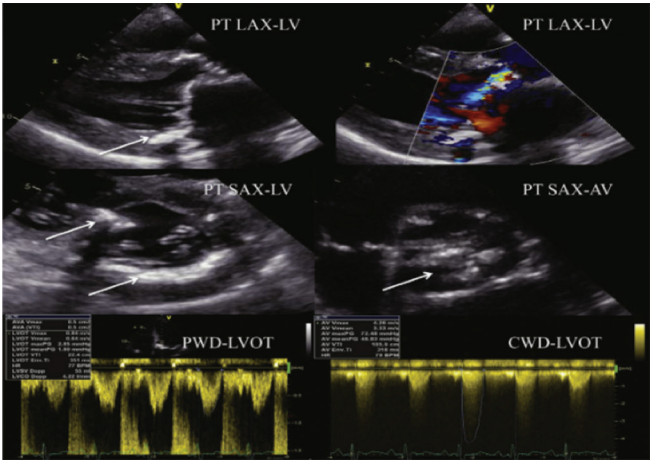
Echocardiographic analysis of a patient with radiation-induced valvular heart disease. Extensive calcifications of the aortic and mitral valve (arrows) and the left ventricle. Significant aortic stenosis and regurgitation
